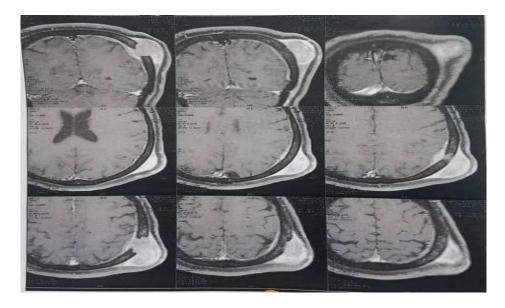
MRI images revealed a left parietal lesion
